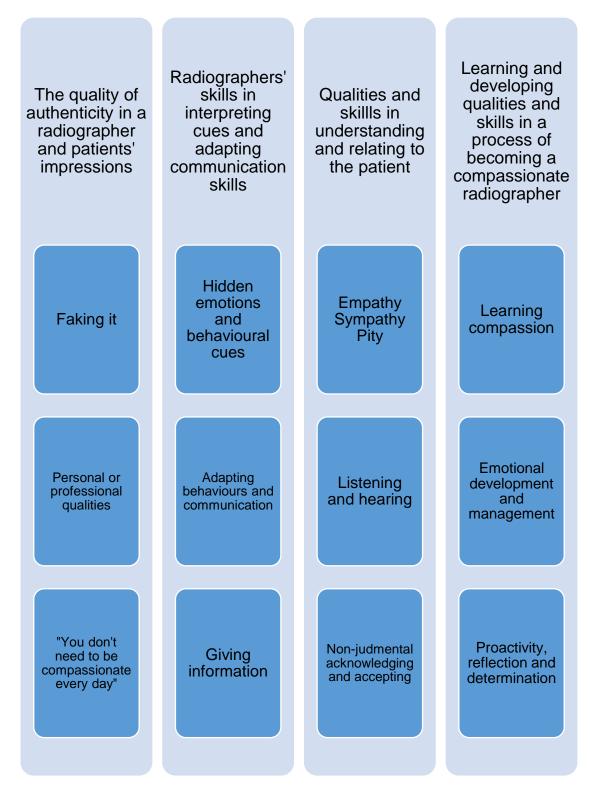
Qualities, skills and attributes associated with a compassionate radiographer
